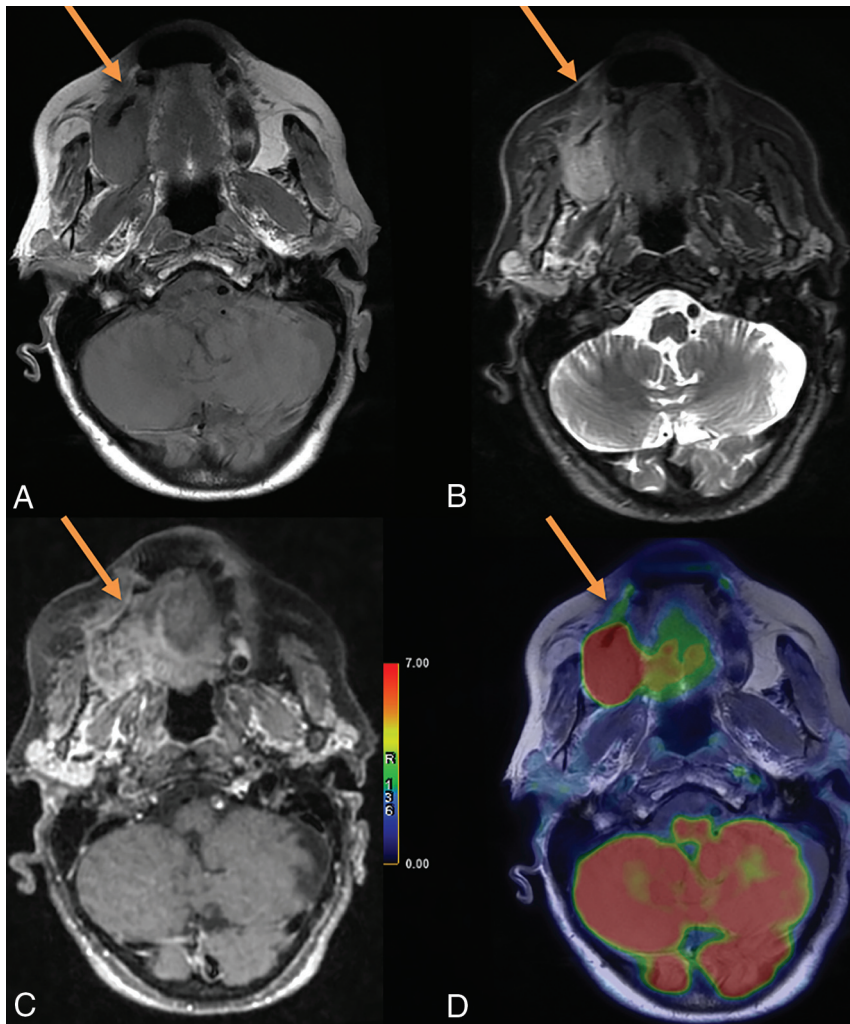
Initial staging of a right maxillary squamous cell carcinoma in an 84-year-old woman. A, Axial T1-weighted spin-echo (SE) sequence. B, Axial T1-weighted fat-saturated sequence. C, Fusion between axial T1-weighted SE sequence. C, 3D T1-weighted fat-saturated SE postcontrast sequence, axial plane. D, Fusion between axial T1-weighted SE sequence and ^{18}F -FDG-PET. Both T1-weighted FDG-PET/MR imaging with and without gadolinium showed right hard palate invasion. The anterior tumor margin (*arrow*) was difficult to define on both contrast-free and postcontrast T1WI (B and D). PET imaging allowed clarification of the lesion margins (A and C).
